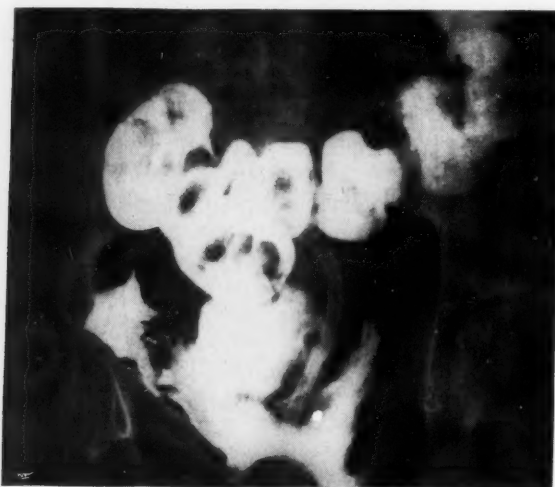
Anteroposterior radiograph after barium-filling of the rectum demonstrating the escape of barium into the infraperitoneal space.
